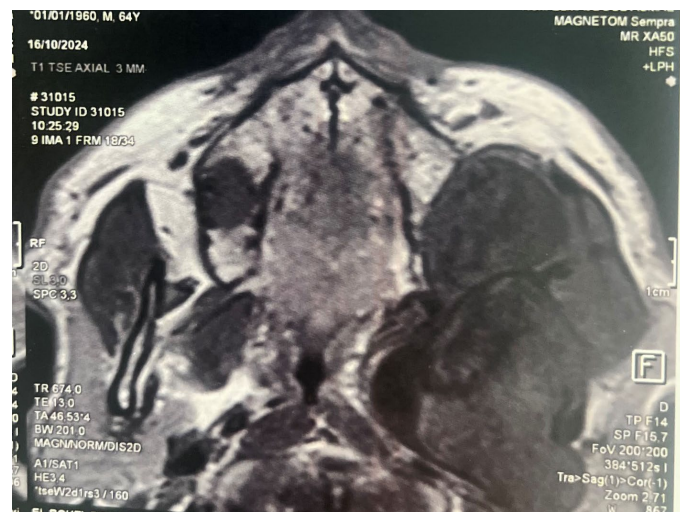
Axial section of a parotid MRI showing the tumor's relationships with the posterior wall of the maxillary sinus, displacement of the ipsilateral pterygoid muscles, and medial extension toward the mucosal pharyngeal space, resulting in narrowing of the pharyngeal space.
